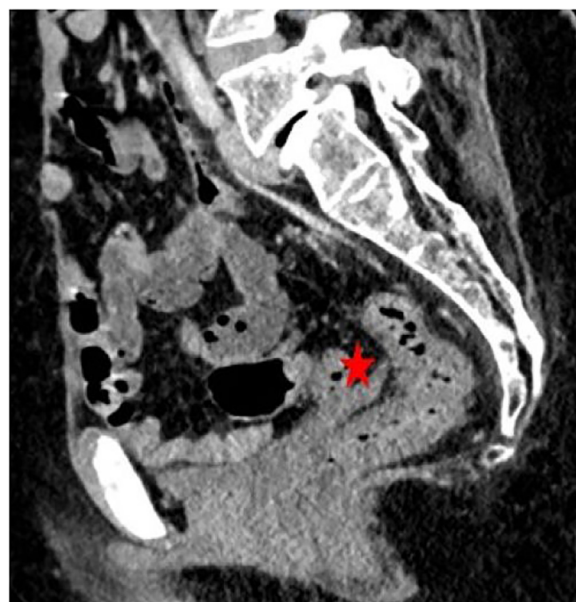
Sagittal section of a CT scan through the pelvis showing an empty uterine cavity.
